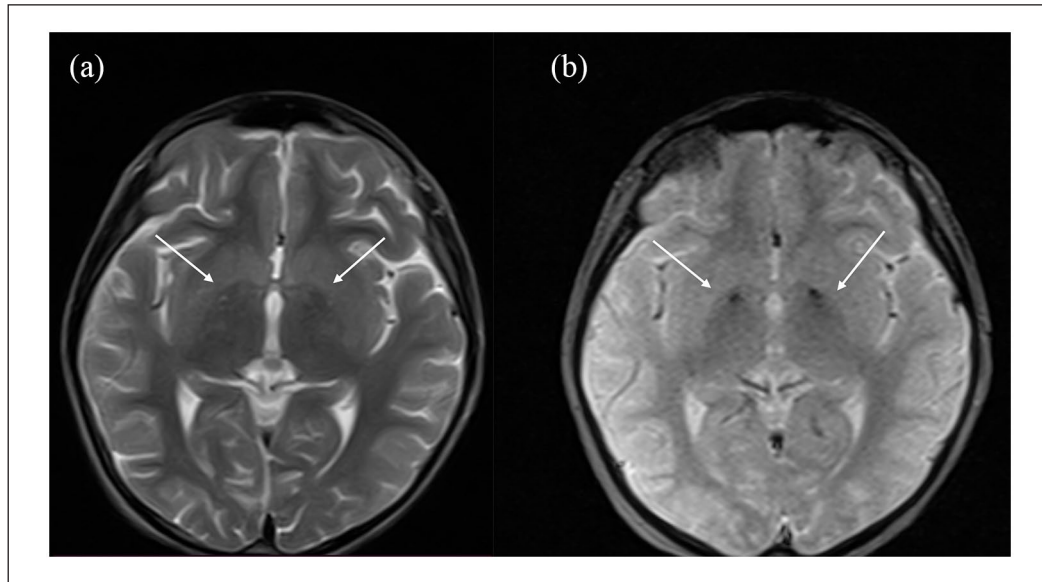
T2-weighted brain (a) and T2-weighted GRE magnetic resonance imaging (b) revealed hypointensity with central hyperintensity in both globi pallidi, indicative of the “eye-of-the-tiger” sign.
